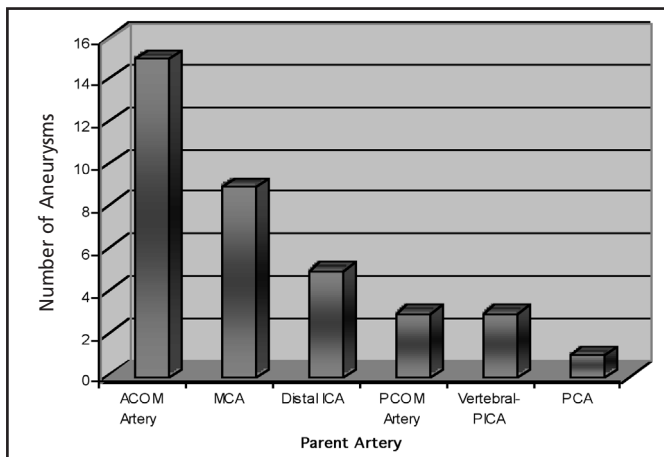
Distribution of Aneurysms Detected with CT Angiography.
